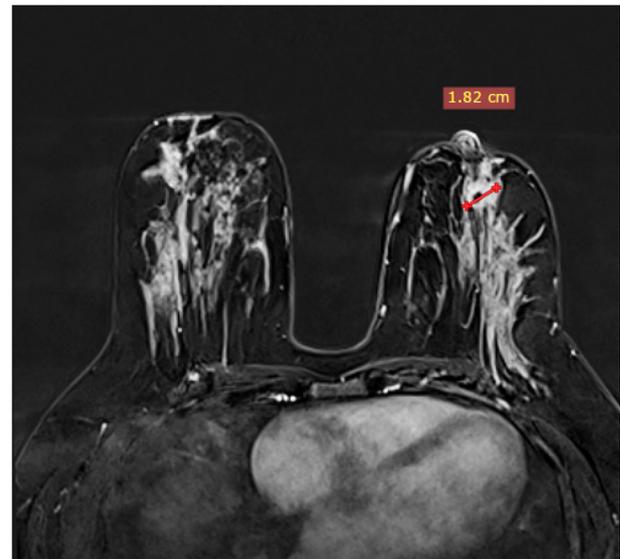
The breast magnetic resonance imaging demonstrates heterogeneous non-mass-like enhancement with a small central mass, measuring 1.82 cm, highlighted in the left breast.
